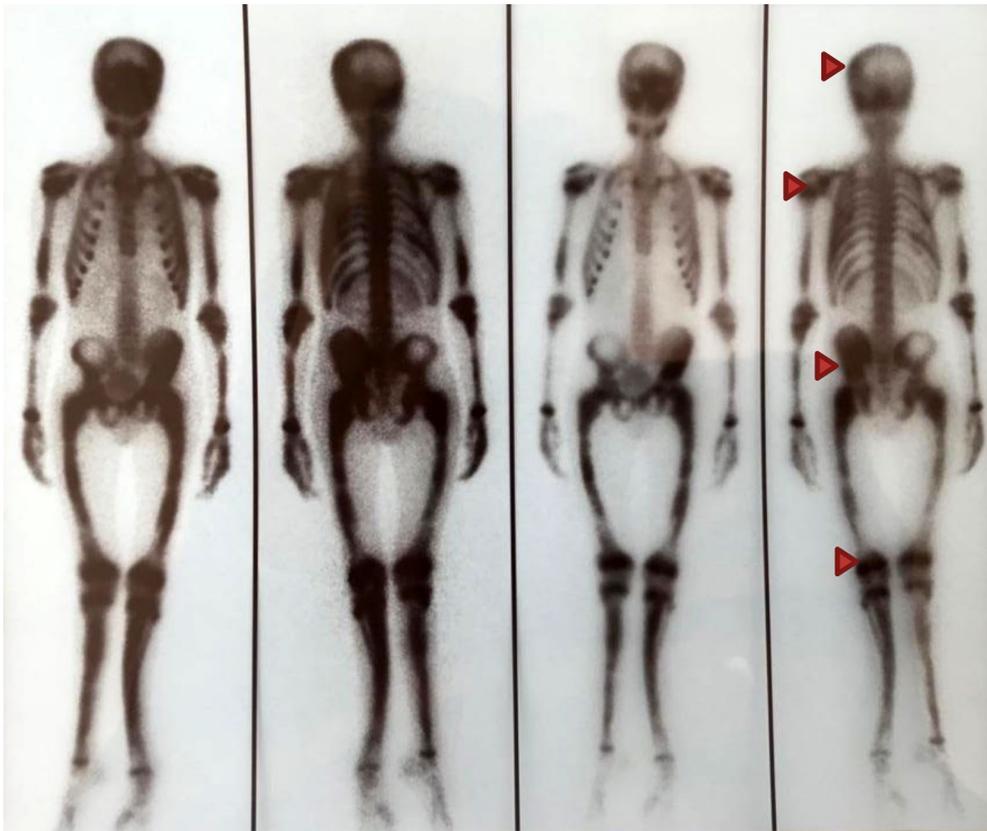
Scintigraphy scan in the areas of fibrous dysplasia. Technetium-99 scintigraphy scan showing increased tracer uptake in areas of fibrous dysplasia, including the craniofacial bones, bilateral upper extremities, bilateral femur, and tibia (red arrowheads).
